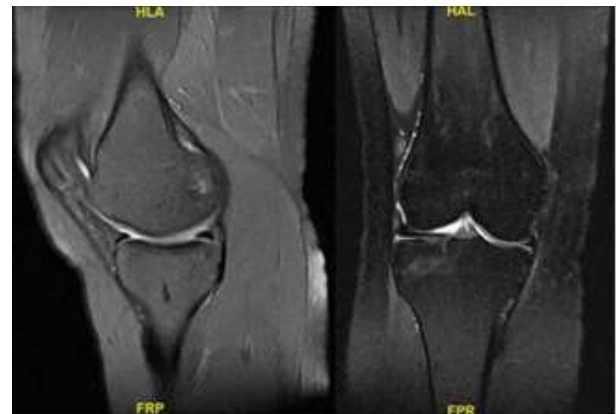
MRI showed no intraarticular signs but in T1 sequences there were multiple, well-defined, millimeter-sized sclerotic areas near the ends of the tibia and femur (osteopoikilosis).
